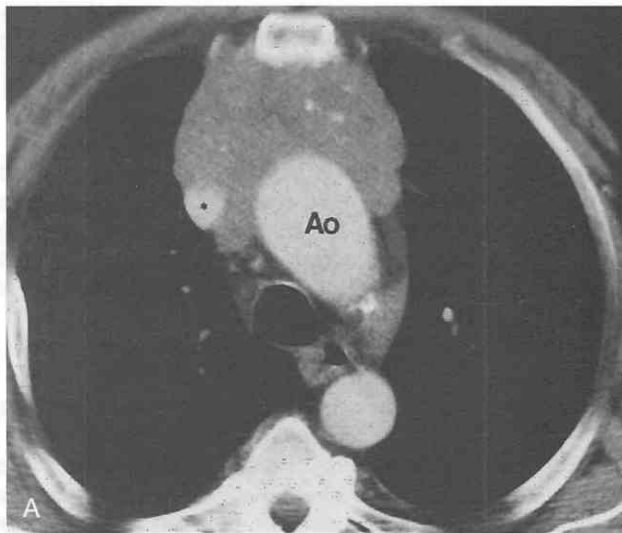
Invasive thymoma. A and B, Contrast-enhanced CT shows heterogeneous anterior mediastinal mass with focal areas of calcification. Note mass extension between superior vena cava (asterisk) and ascending aorta (Ao in A) and contiguous extension to hemidiaphragm (arrowheads in B). L, liver.
